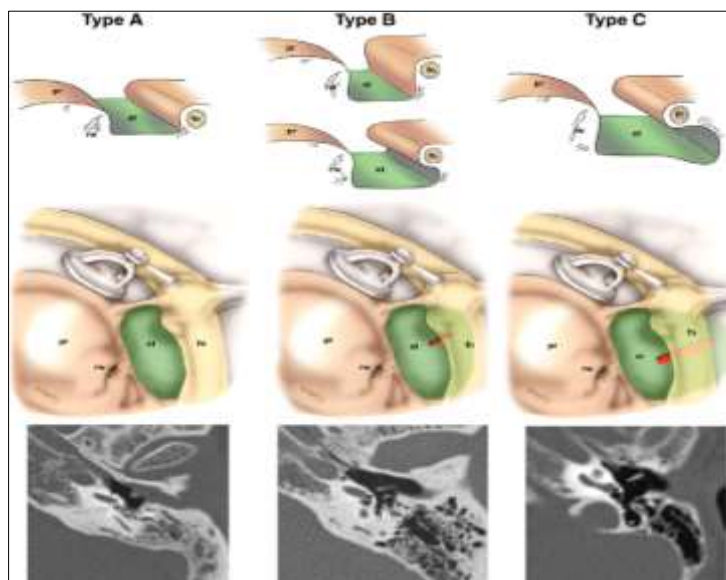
Classification of tympanic sinus depth based on axial CT scan:
